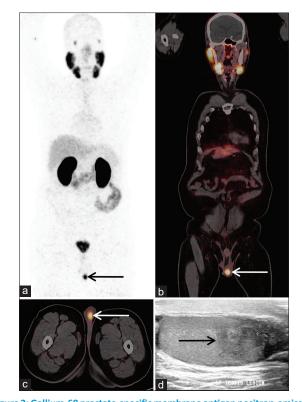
Gallium-68 prostate-specific membrane antigen positron-emission tomography computed tomography maximum intensity projection (a), fused coronal (b) and fused axial (c) images. Images showing a prostate-specific membrane antigen-avid lesion in the left testis. A correlative ultrasonography of the scrotum showing a hypoechoic lesion in the left testis (d)
